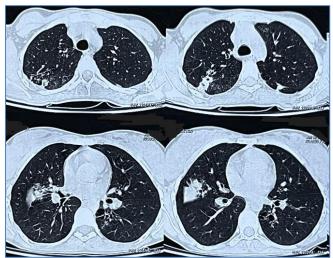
HRCT Thorax showing round opacity at lateral aspect of horizontal fissure mimicking 'round pneumonia'
